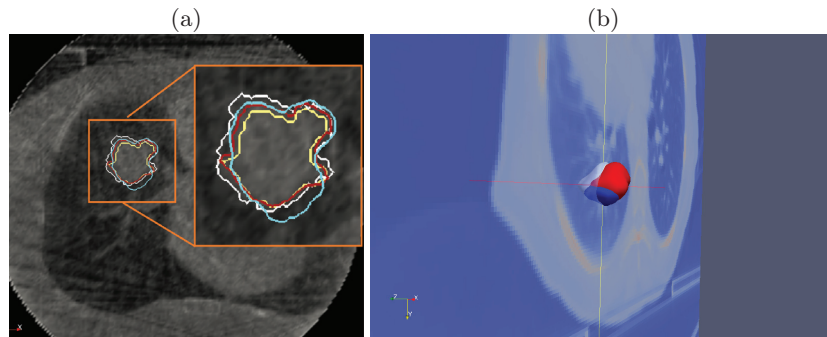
(a) Manual segmented contours in the reconstructed CBCT at specific phase. They were used for 3D CoG calculation. (b) Tumor meshes in the mean CT (gray), in the CBCT at the EE respiratory phase (blue) and in the estimated CT (red). \vec{X} : Left to Right; \vec{Y} : Anterior to Posterior; \vec{Z} : Superior to Inferior.
